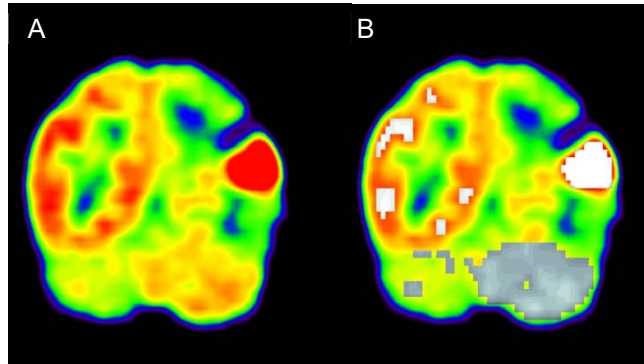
Coronal view of (a) the FDG-PET scan, and (b) quantification of the glucose metabolic rate. Widespread diaschisis is seen in the ipsilateral cerebral hemisphere and the contralateral cerebellar hemisphere, to the supratentorial glioblastoma. The cerebro-cerebellar diaschisis was confirmed by a lower total hemispheric glucose metabolic ratio (THGr) in the cerebrum (<0.61) and the cerebellum (<0.84). Tumour had recurred after resection, and the patient died 30 days after the scan was performed.
